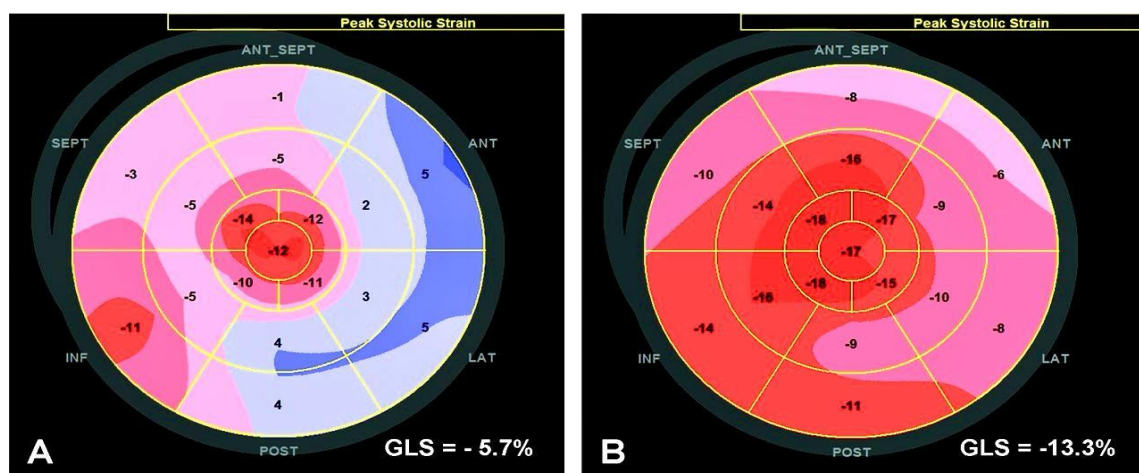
LV global longitudinal strain measured by speckle tracking echocardiography in a patient with severe aortic stenosis before (A) and 1 month after TAVI (B). Before TAVI, the LVEF was 30% and the mean
